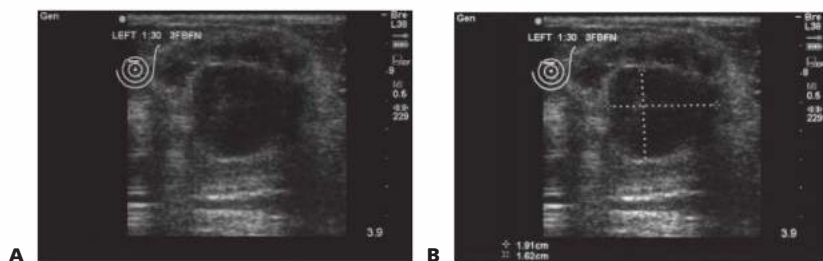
• A,B. Classic ultrasound image of fibroadenoma demonstrating well-defined borders and homogeneous solid mass with edge shadowing.
